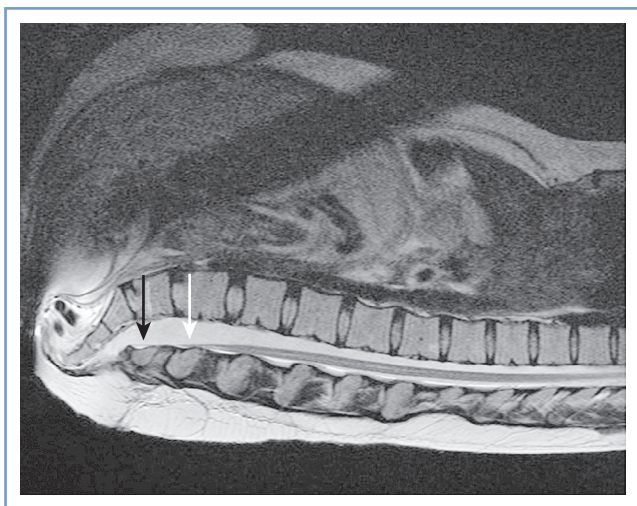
■ Magnetic resonance image of the spine in a 27-year-old woman with history of a lumbar myelomeningocele excised as a neonate, with residual bladder dysfunction. A tethered spinal cord is present with a typical posterior low-lying position. The *white arrow* indicates the termination of the conus medullaris at L4 to L5, and the *black arrow* indicates the filum terminale located at L5 to S1. (This patient had a vaginal delivery at term, requiring only nitrous oxide for analgesia.)
